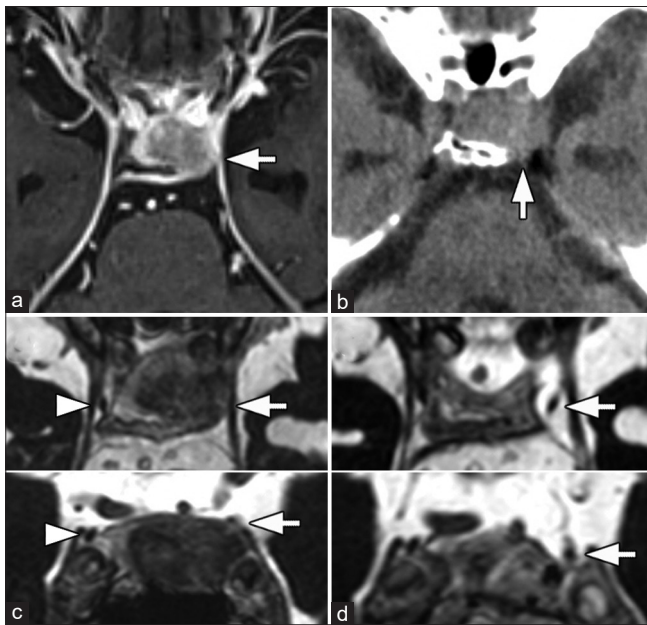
(a) Axial gadolinium-enhanced T1-weighted magnetic resonance (MR) image showing homogeneously enhancing pituitary tumor protruding latero-posteriorly to the left cavernous sinus (arrow) with no apparent findings of pituitary apoplexy. (b) Computed tomography scan showing erosion of the left posterior clinoid process (arrow). (c) Preoperative constructive interference in steady-state (CISS) MR images (axial and coronal views) showing compression of the left oculomotor nerve by the tumor (arrow). The right oculomotor nerve is visible (arrowhead). (d) Postoperative CISS MR images (axial and coronal views) showing the left oculomotor nerve at the oculomotor triangle (arrow).
